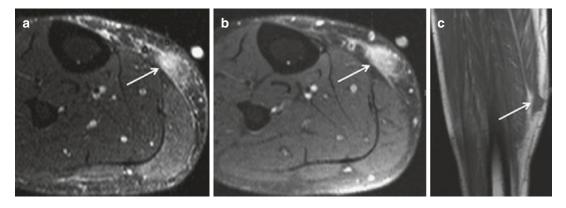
A 46-year-old male with pleomorphic hyalinizing angiectatic tumor in the calf. (a) Axial T2-weighted MR image (STIR). (b) Axial T1-weighted MR image post-contrast. (c) Coronal T1-weighted image. The STIR image (a) shows a subcutaneous hyperintense lesion (*arrow*) overlying the medial soleus and medial head of the gastrocnemius muscles. Axial post-contrast image (b) at the same level shows relatively homogeneous
